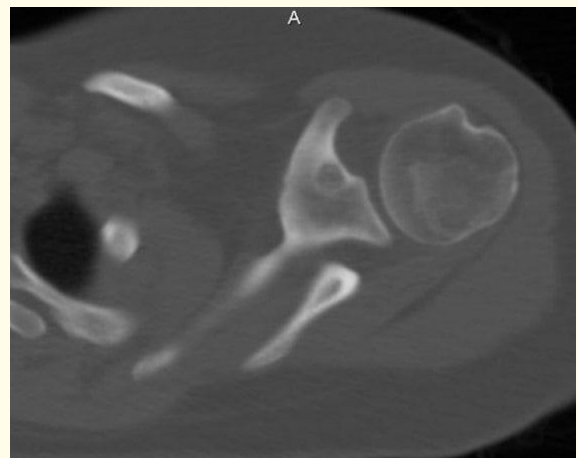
Computed tomography of the shoulder shows a well-defined rounded lytic bone lesion, juxta cortical, 7mm maximal diameter containing punctiform calcifications surrounded by a small sclerotic reaction.
